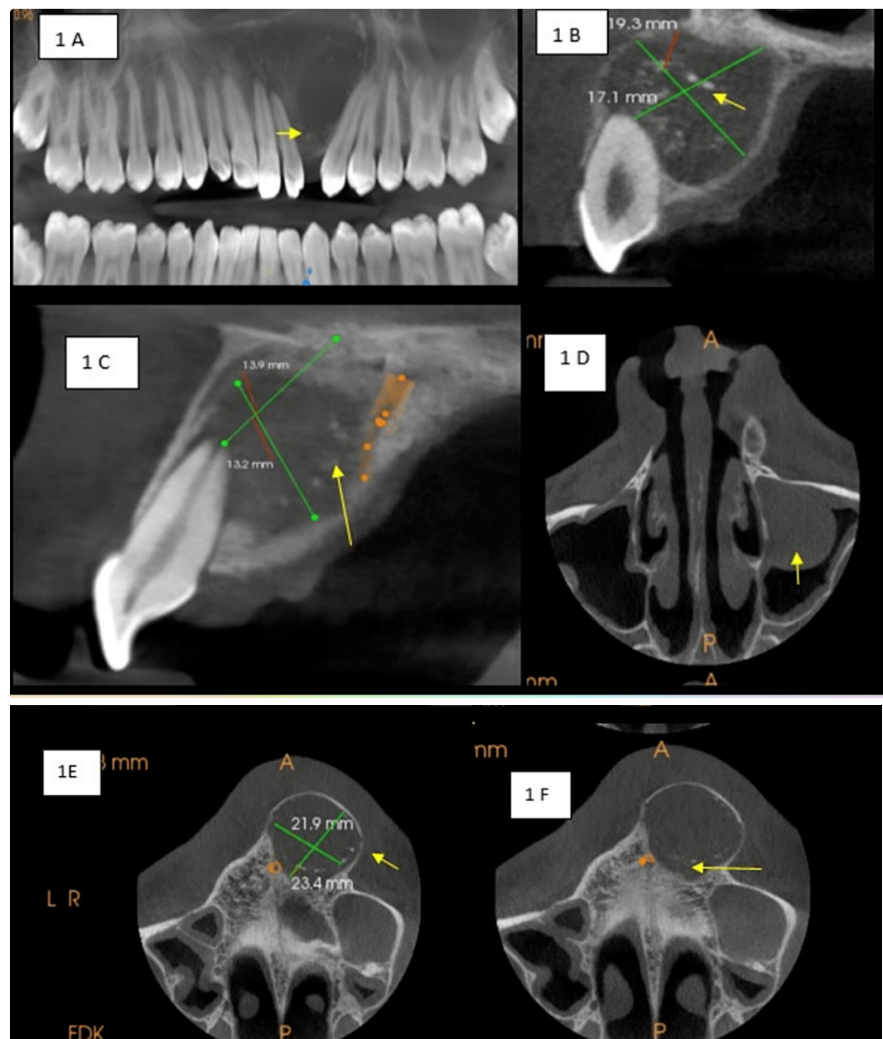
A. CBCT Panoramic image shows radiopaque flecks and pathological migration between 22 and 23. B. CBCT sagittal section shows expansion of lingual cortical plate and destruction of labial cortical plate. C. CBCT Sagittal section shows destruction of floor of nasal cavity and nasopalatine canal. D. CBCT Axial section shows mucosal thickening within left maxillary sinus E. F. shows destruction of anterior region of hard palate
